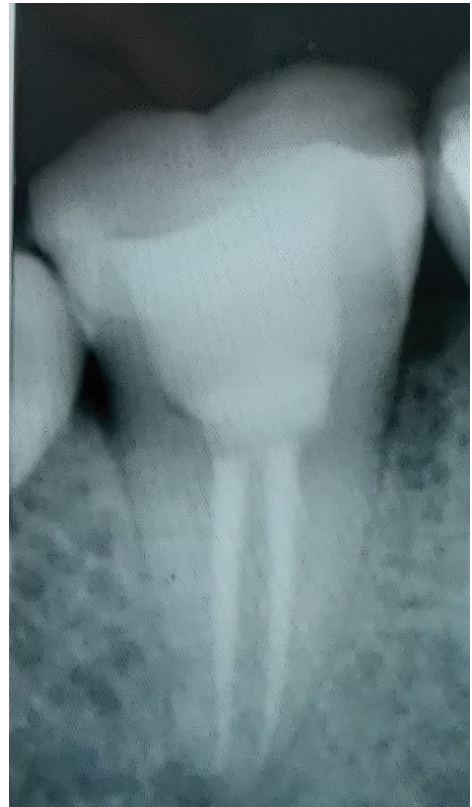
18 month follow up radiograph.
